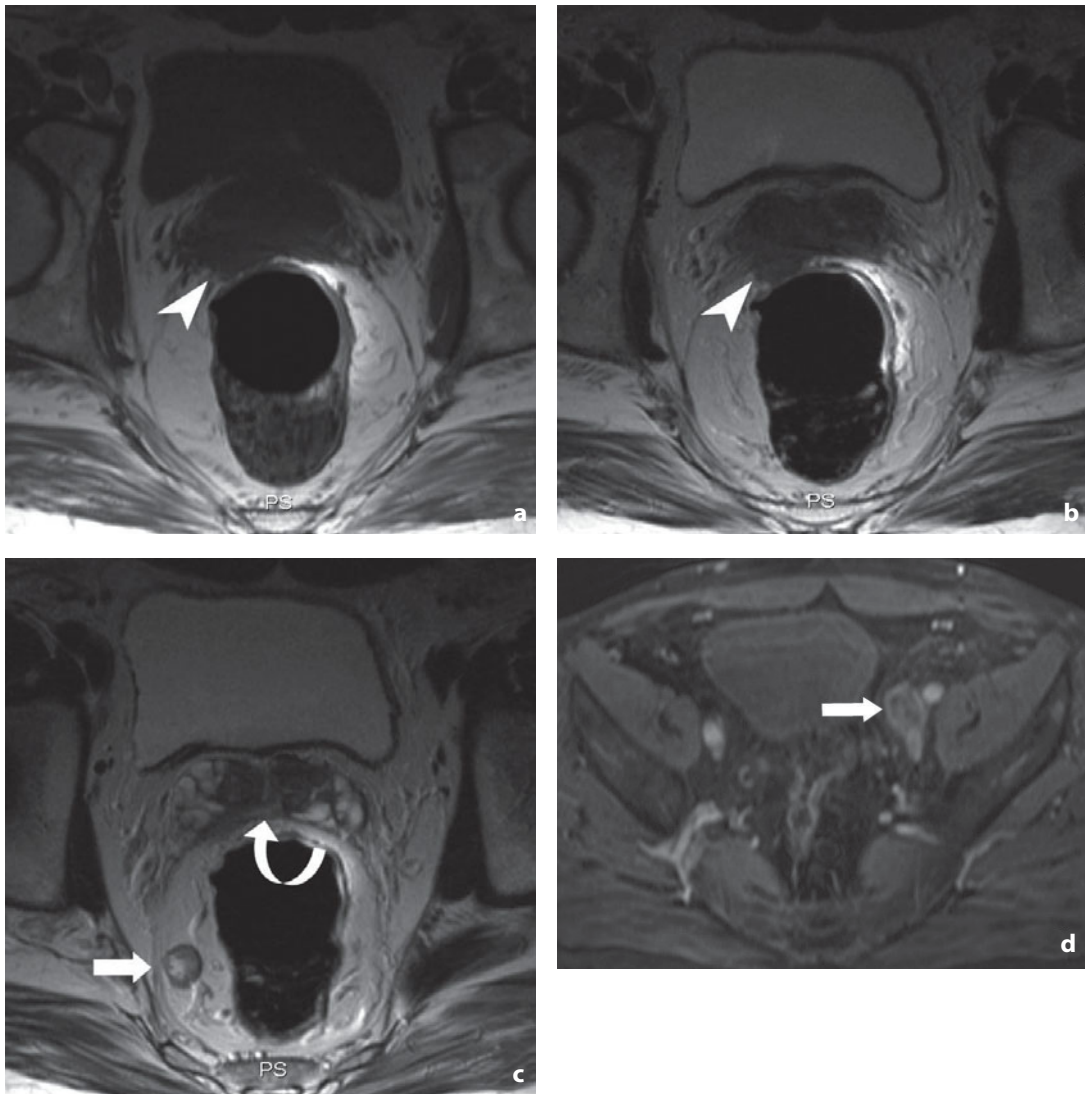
Magnetic resonance. Lymph node metastasis in T3b carcinoma of the prostate. Axial T1- (a) and T2-weighted images (b,c) show the tumor invading the perirectal fat (*arrowheads*) and the seminal vesicles (*curved arrow*) with lymph node metastasis (*arrow*) in the right ischioirectal fossa. d Another necrotic metastatic lymph node (*arrow*) can be visualized in the left external iliac chain
